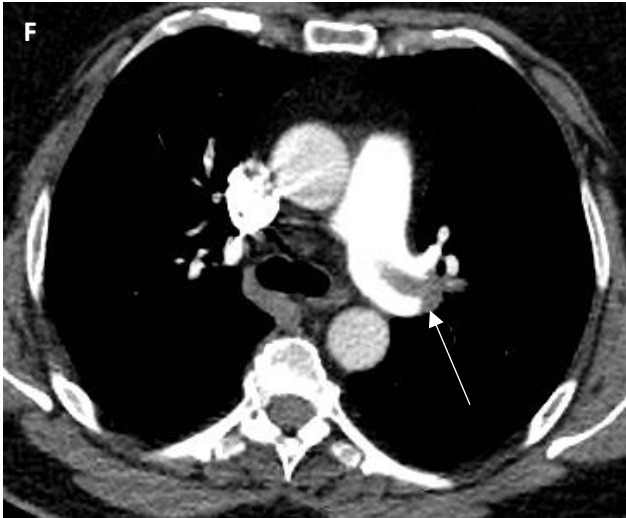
F - CT- angiography, axial plane, filling defect occluding the left pulmonary artery (white arrow).
